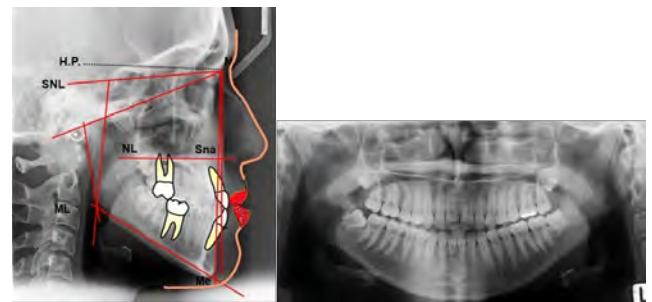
a: Cephalometric tracing of the radiograph prior to orthodontic decompensation. b: Orthopantomogram
